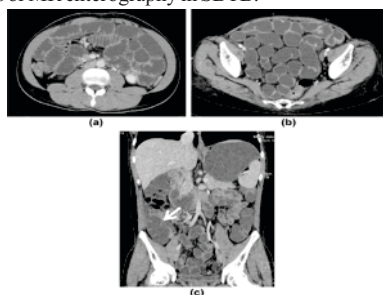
Normal small bowel. (a) Axial CT image shows normal jejunal loops. (b) Axial CT image shows normal ileal loops. (c) Coronal CT image shows normal ileocaecal junction (arrow).
